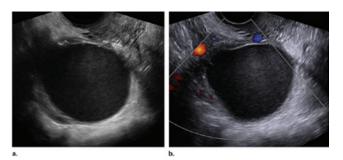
Transverse grayscale (a) and color Doppler (b) showing the presence of a unilocular cyst containing homogeneous low-level echoes and no internal vascularization on color Doppler.⁷
